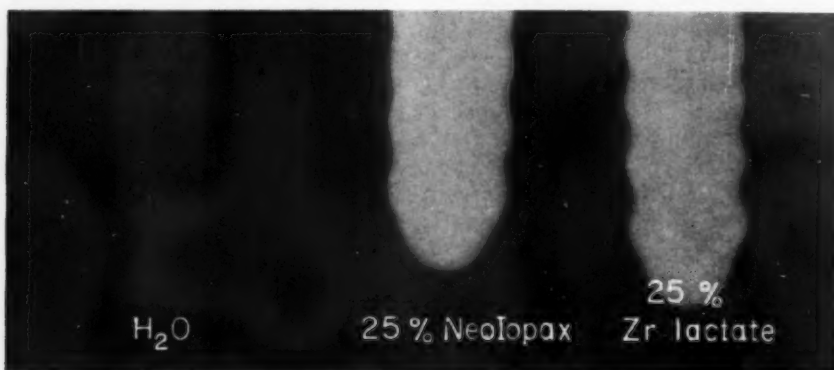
Radiograph in air, at 30 kvp, of finger cots containing water, Neo-Iopax, and 25 per cent zirconium lactate. Note similarity of densities of the Neo-Iopax and the zirconium compound.
